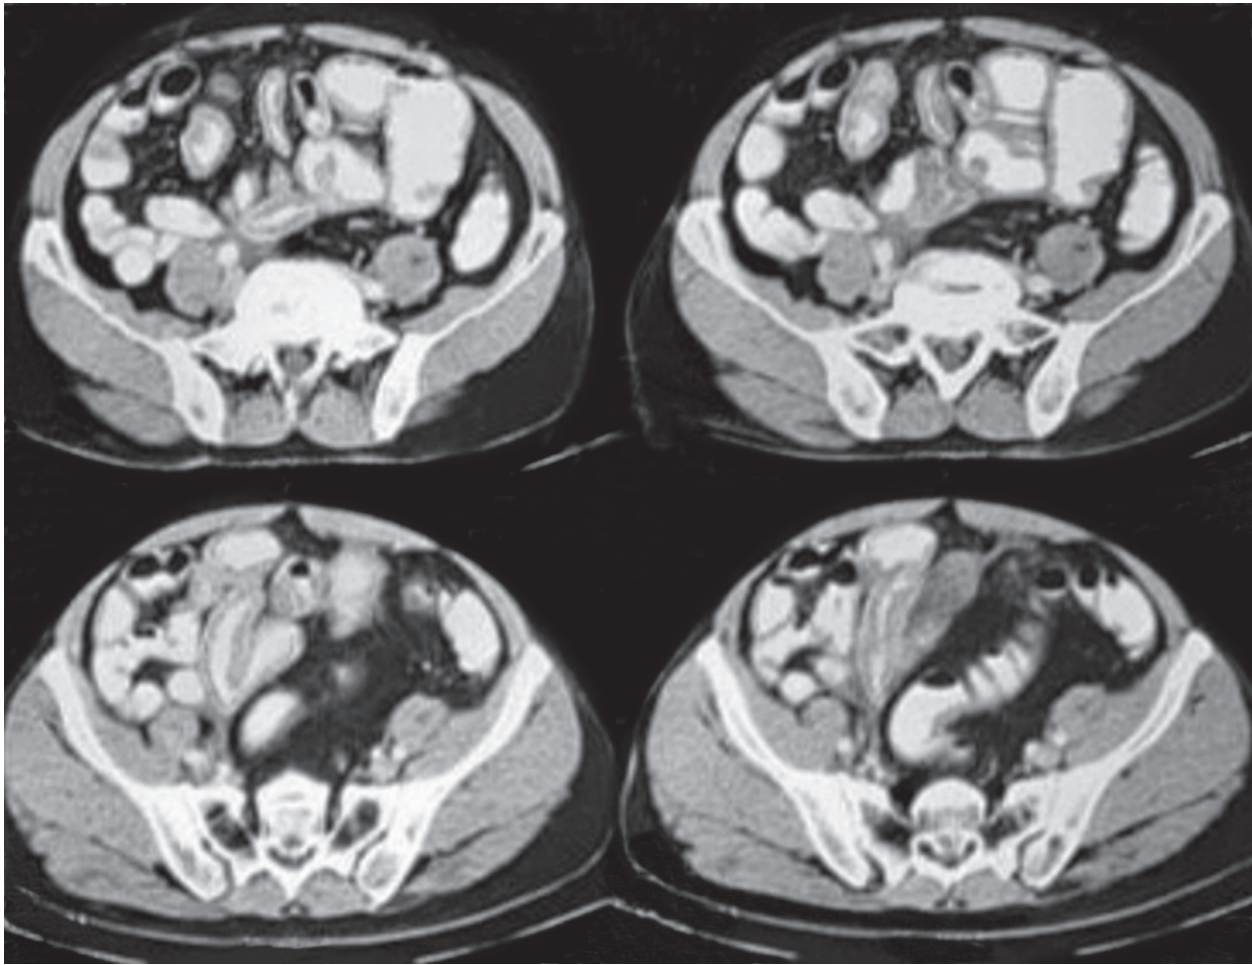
CT scan raised preoperative suspicion of the abdominal cocoon, because of circumferential thickening of small bowel loops and encasement by fine membrane along with a dilated proximal and mid-ileal loop
